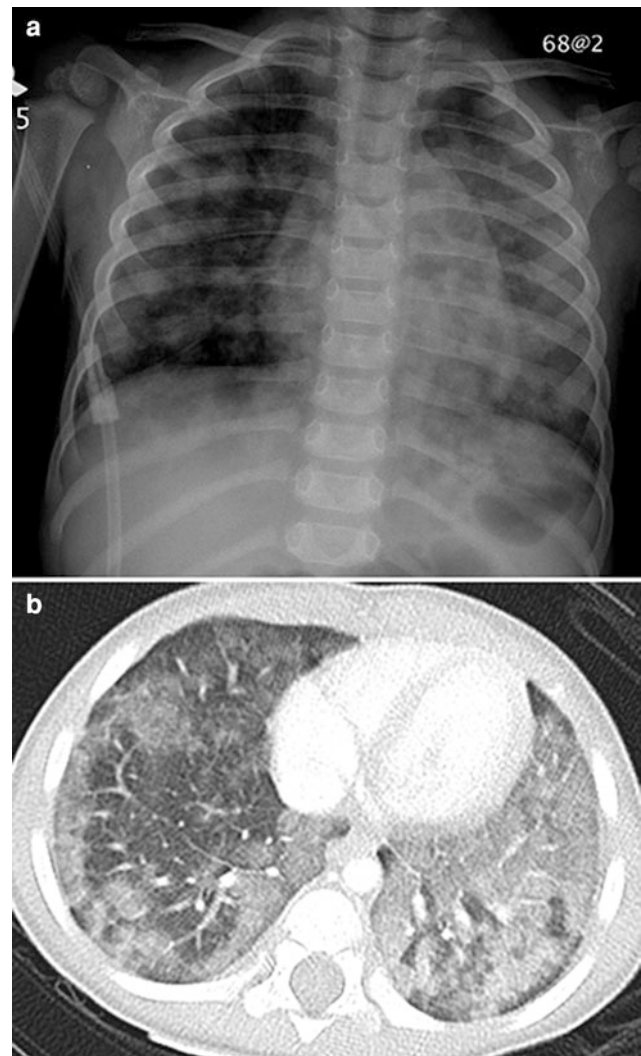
Idiopathic pulmonary hemosiderosis. A frontal CXR (a) of a 1-year-old with anemia and a corresponding axial chest CT image (b) show patchy pulmonary airspace opacities, more extensive on the left, related to intra-alveolar pulmonary hemorrhage
